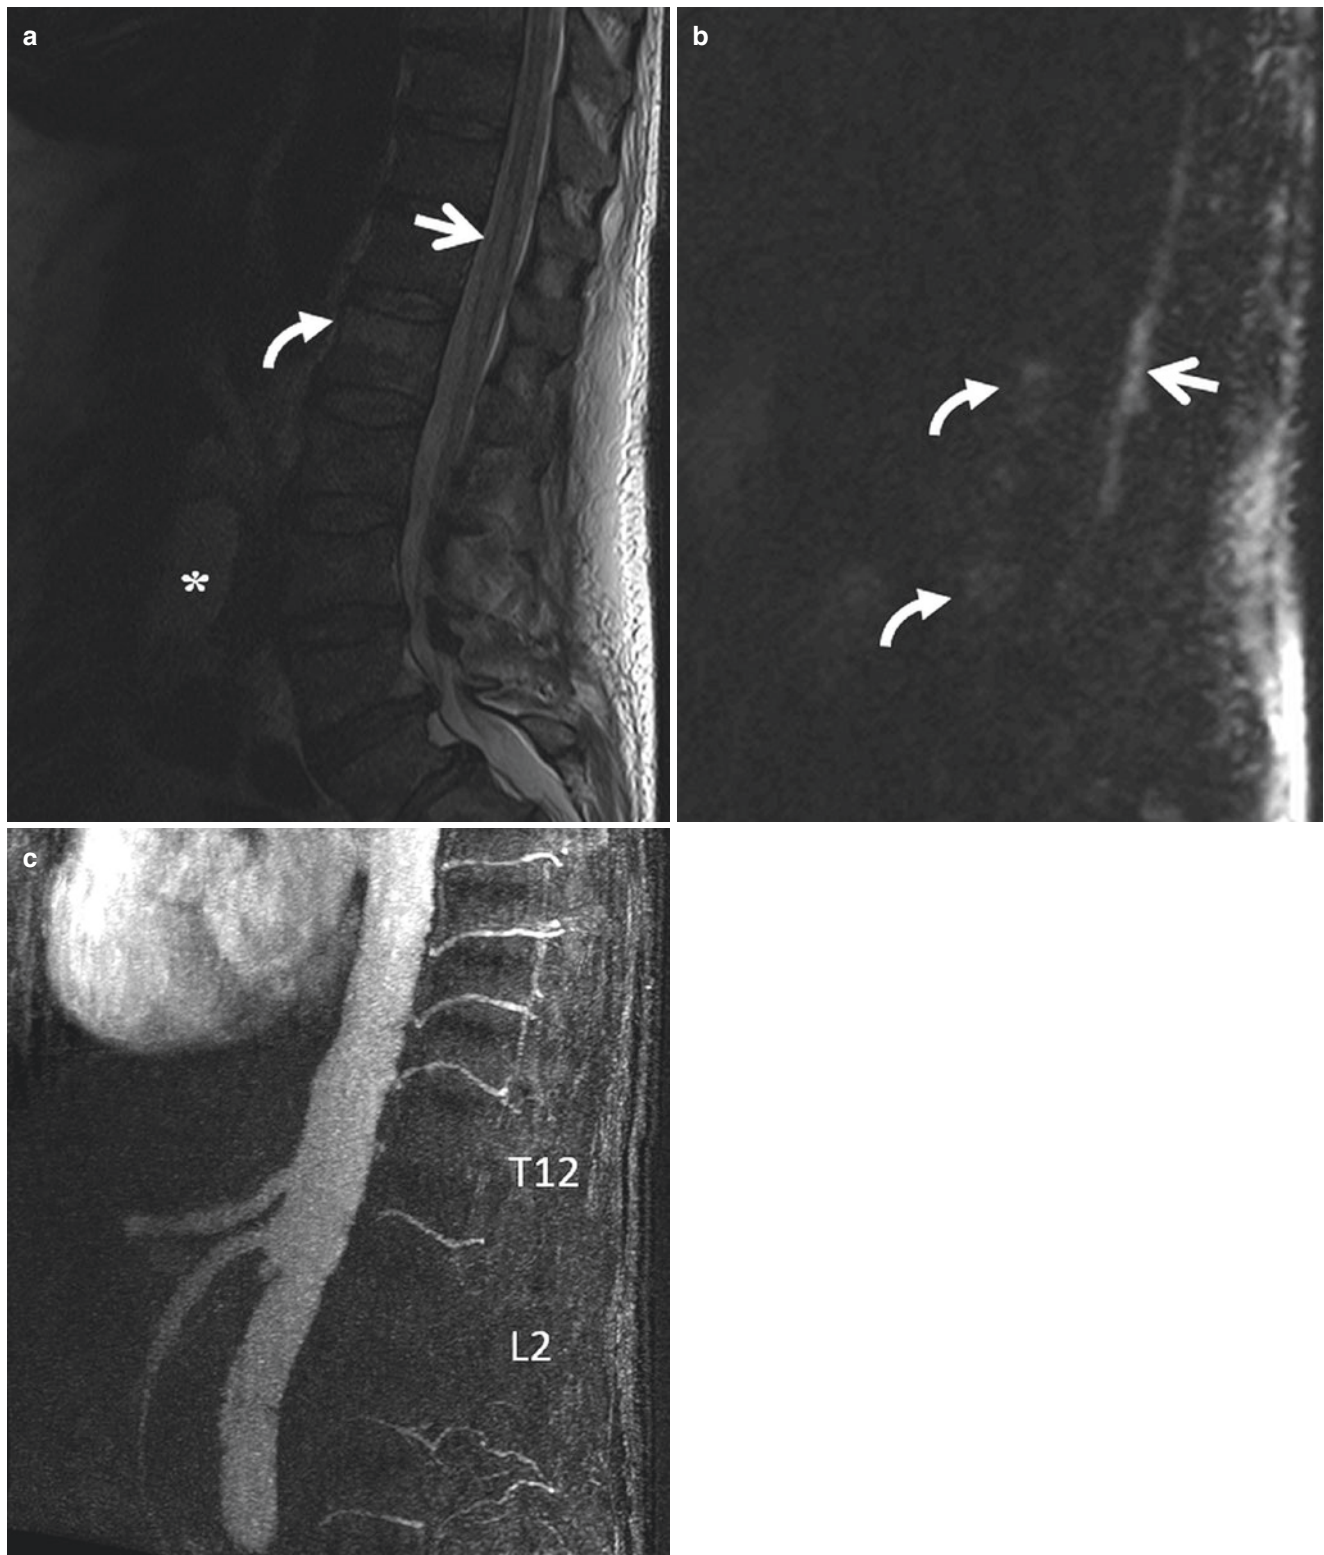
Cord infarction. A 61-year-old with lower extremity weakness after surgical repair of abdominal aortic aneurysm. (a) Sagittal T2 MRI shows hyperintensity and mild expansion of conus from T11 to L1 (*arrow*). Abnormal bone marrow signal of L1 vertebral body, suggestive of bone infarction (*curved arrow*). Note abdominal aortic aneurysm (*).
